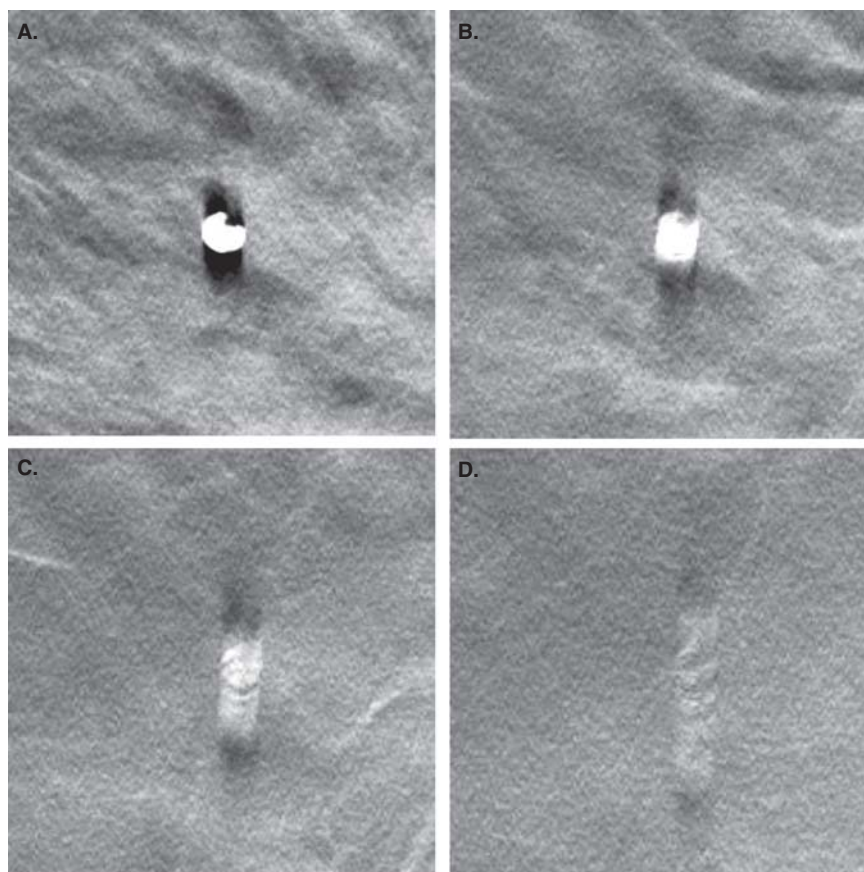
A millimetre-sized calcification seen in different slices: (A) in the focus plane, (B) 6 mm from the focus plane, (C) 10 mm from the focus plane, and (D) 17 mm from the focus plane. The scanning direction of the X-ray tube is from top to bottom.
